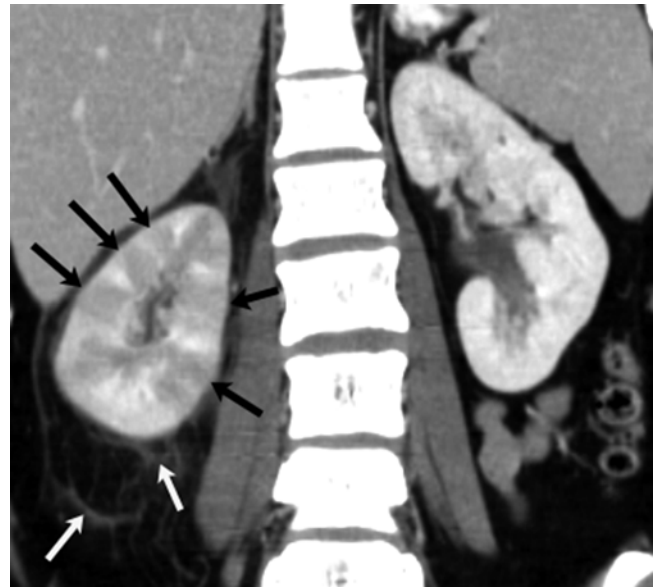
Pyelonephritis. Coronal reformatted image from CT performed with intravenous contrast demonstrates multiple wedge-shaped areas (*black arrows*) of parenchymal hypoenhancement and perinephric stranding (*white arrows*)
